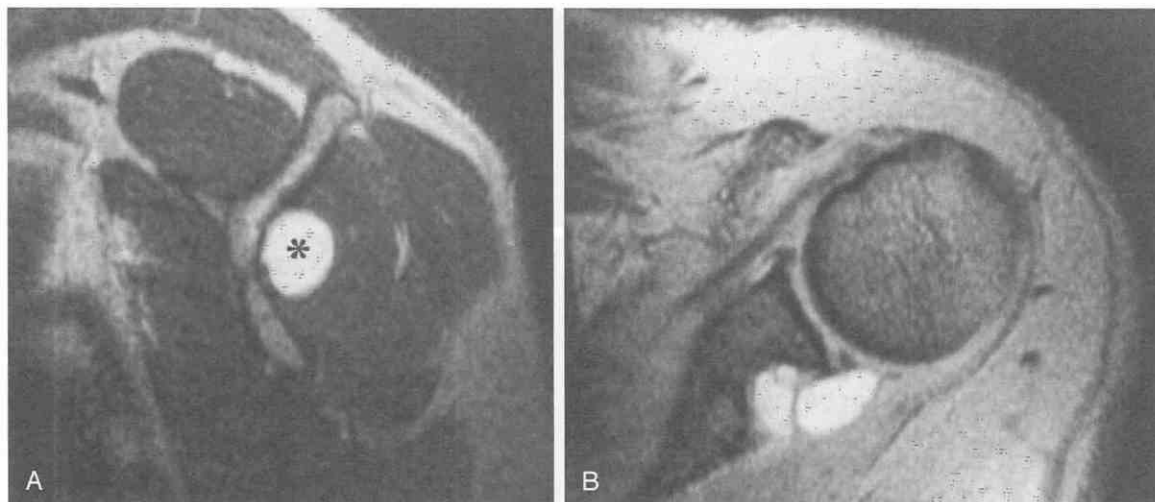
Spinoglenoid notch ganglion. A, T2-weighted (TR = 2500 msec, TE = 70 msec) sagittal oblique image. A single, rounded, hyperintense mass (asterisk) is present in the spinoglenoid notch of this young man who presented with shoulder pain. B, Gradient-echo axial image. At this level, the lesion is composed of multiple smaller masses. On proton-density images, this mass was intermediate in signal, approximately isointense with muscle. This location and appearance are typical of a spinoglenoid notch ganglion.
